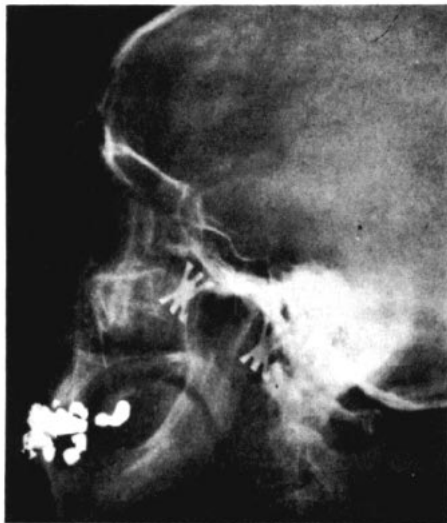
Photograph of x-ray showing complete fracture of maxilla.
